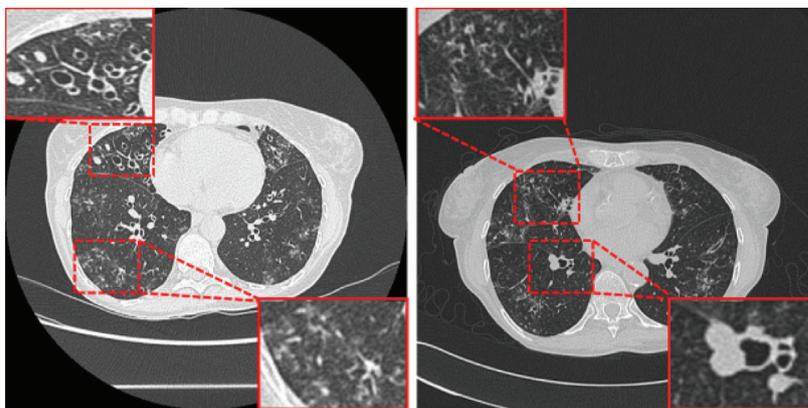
High-resolution chest computed tomography shows extensive bronchiectatic lesions and tree-in-bud opacities with linear branching pattern and nearly uniform distribution in the right middle and lower lobe, as well as the lingula and the left lower lobe, indicating architectural distortion and terminal airway mucous impaction with adjacent peribronchiolar inflammation. Insets are showing bronchiectatic lesions and tree-in-bud opacities (left panels and right upper panel) as well as signet-ring shaped bronchiectasis (right lower panel).
